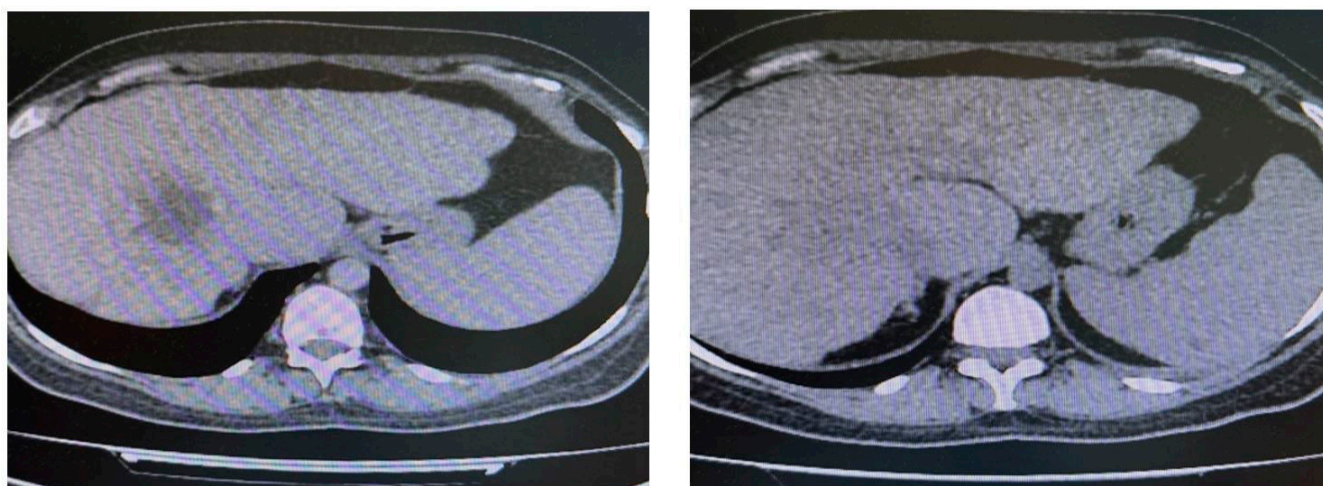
Postoperative CT scan: Nodular lesion (73.63 mm, segment VIII)
